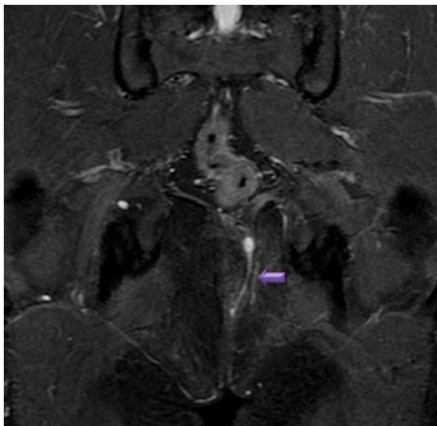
Coronal T2 weighted FS MR image showing simple linear inter-sphincteric fistula on left side - GRADE 1
